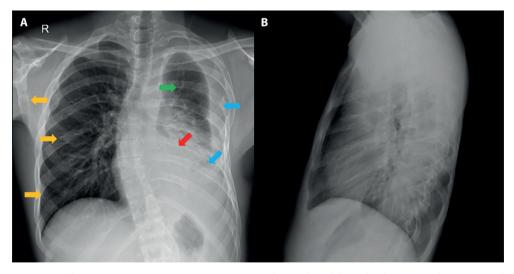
Chest X-ray. A. Posteroanterior projection (R= right side). Right thoracic scoliosis. Central trachea with patent source bronchi. The right lung hilum has a normal configuration, the left lung hilum cannot be assessed. Pleural effusion on the left side is evident. The cardiac silhouette is appreciated with limited evaluation due to haziness of the left lung field (red arrow). Diffuse thickening of the left pleural space with complete atelectasis of the lower lobe is observed (blue arrow). There are mixed opacities with predominant alveolar involvement affecting the left upper lobe (green arrow). Multiple lytic lesions with sclerotic and well-defined edges are seen in bone structures (yellow arrows). B. Lateral projection.
